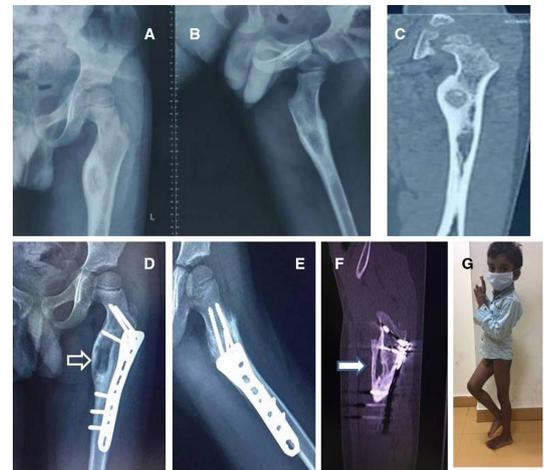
Antero-posterior and lateral radiographs of the left hip child showing sclerosis in the anteromedial aspect of the left lesser trochanter, nidus surrounded by the reactive bone of sclerosis (A, B); CT scan images showing eccentric lytic lesion with reactive bone sclerosis extending below lesser trochanter (C); follow-up radiograph showing bone healing (hollow arrow) in anteroposterior and frog lateral views with the proximal humerus internal locking system plate in-situ (D, E); reduction of cavity in coronal CT cuts (F-solid arrow); and clinical picture showing single leg stance (G).
